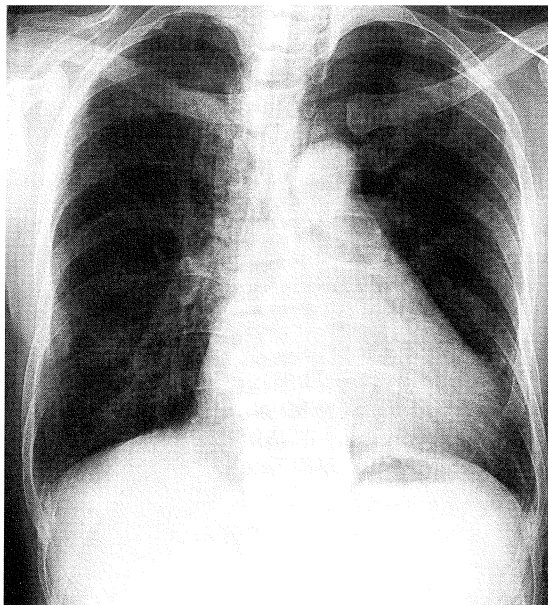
Radiograph of the chest
